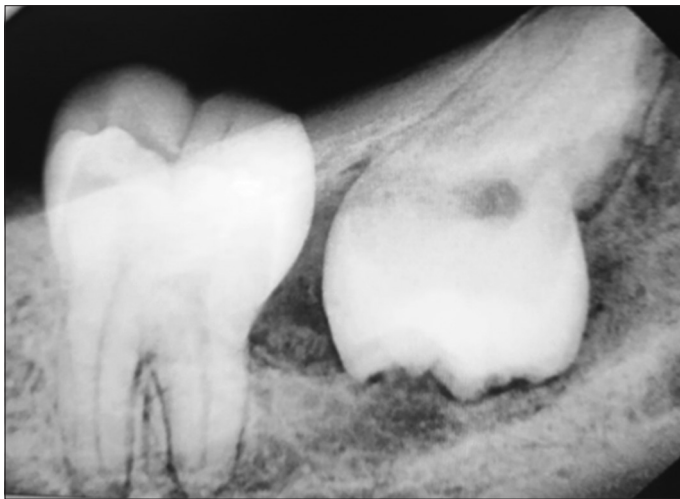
The radiographic image of the inverted impacted mandibular third molar
